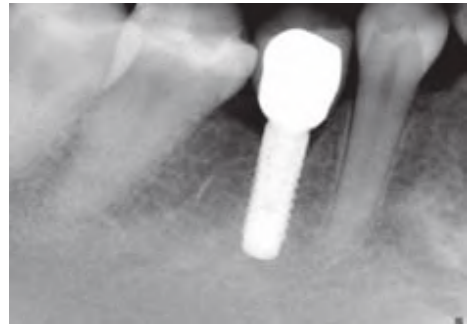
Radiograph of the final prosthesis on the day of delivery
